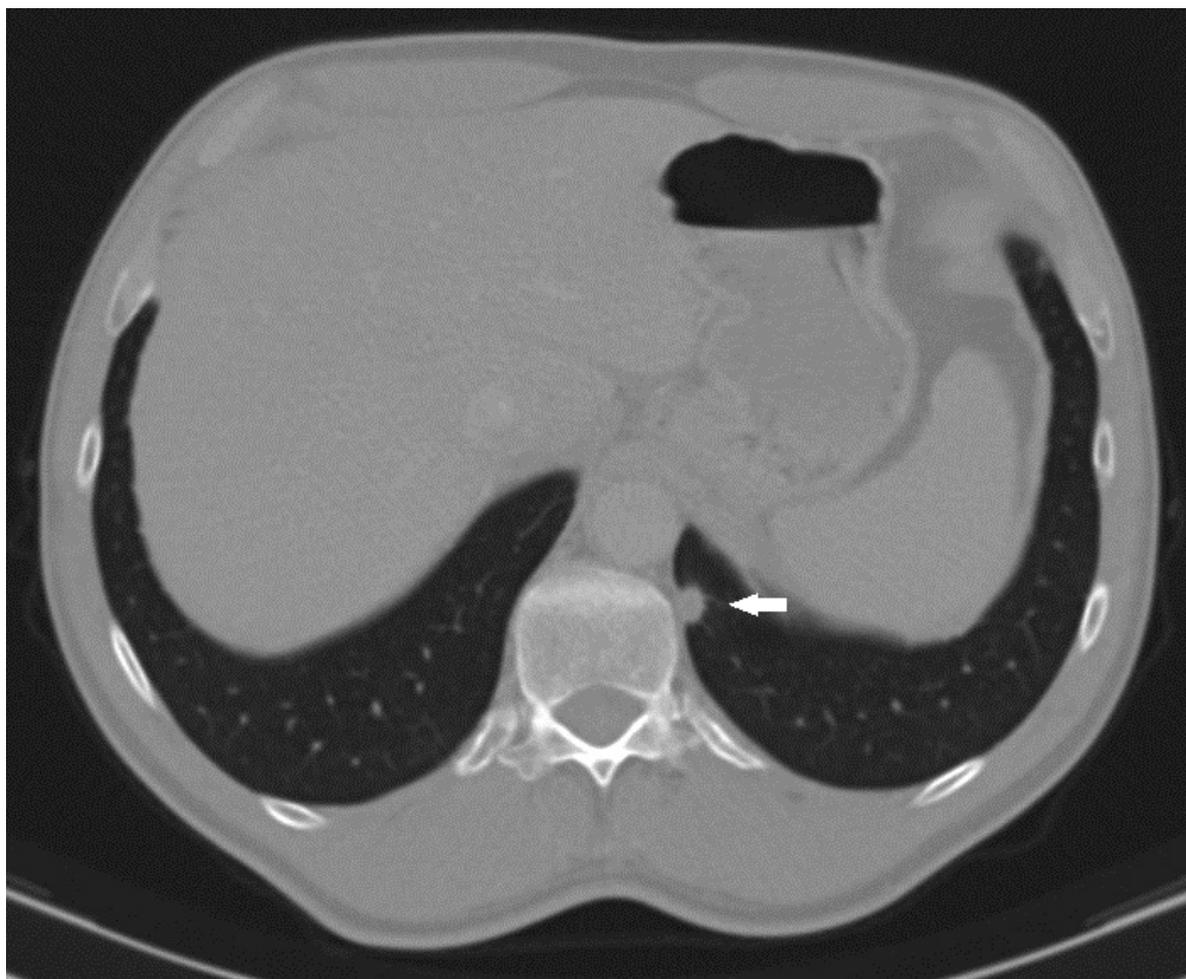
Chest CT of a 58-year-old male patient (smoker) with left lower lobe tuberculoma. The incidentally found spiculated pulmonary nodule (arrow) was suspected to be a primary lung cancer.
